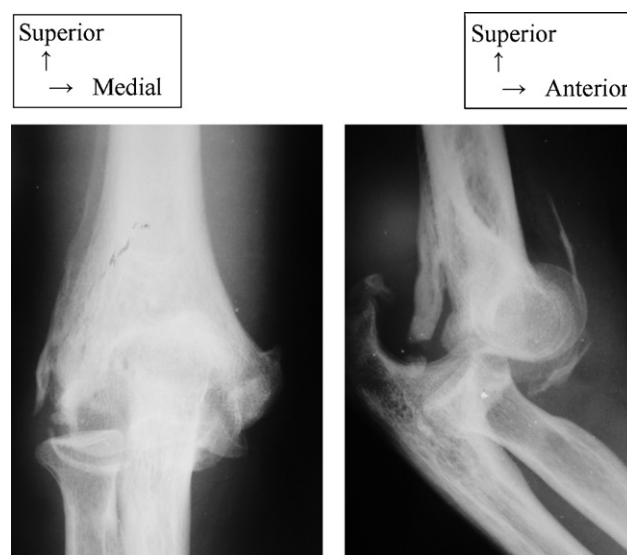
A/P and lateral X-rays of a patient with posterior dislocation of the right elbow and heterotopic ossifications.
